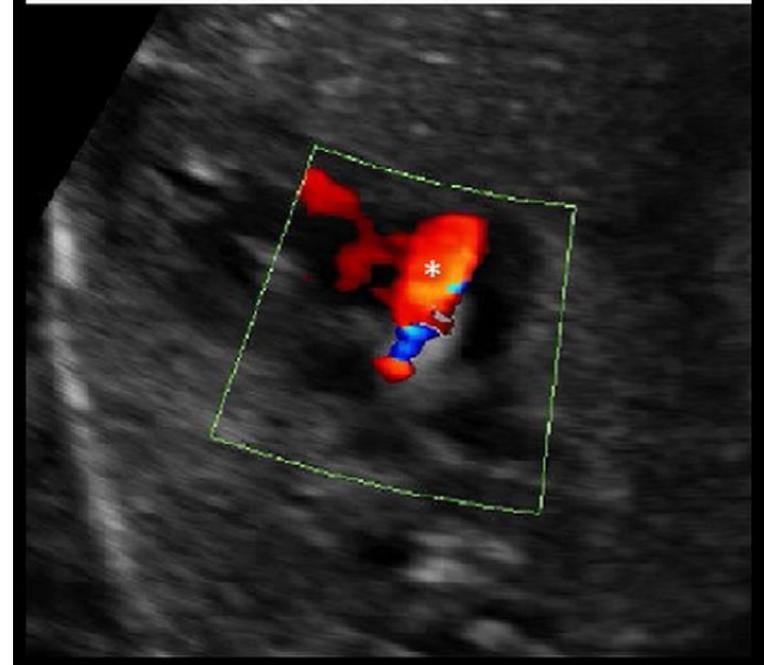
Appearance of hypoplastic left heart syndrome with intact atrial septum after stent angioplasty of the atrial septum. The top panel demonstrates a two-dimensional image of the atrial septum stent. The bottom panel demonstrates a relatively broad jet of accelerated left-to-right flow across the stented atrial septum. LA = left atrium; RA = right atrium; RV = right ventricle, *left atrium-to-right atrium color Doppler jet
